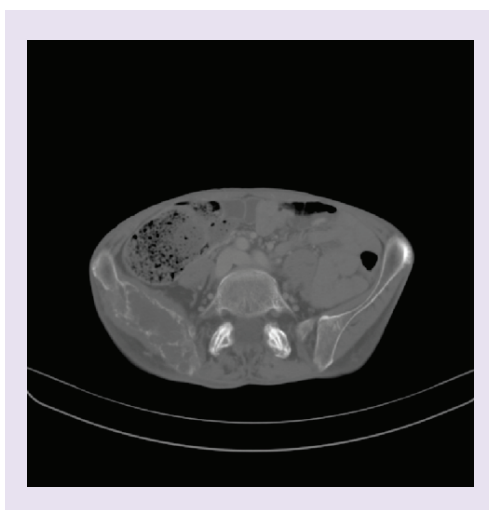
CT scan after embolization demonstrates response of right iliac metastasis with necrosis of the cranial portion of the lesion.
